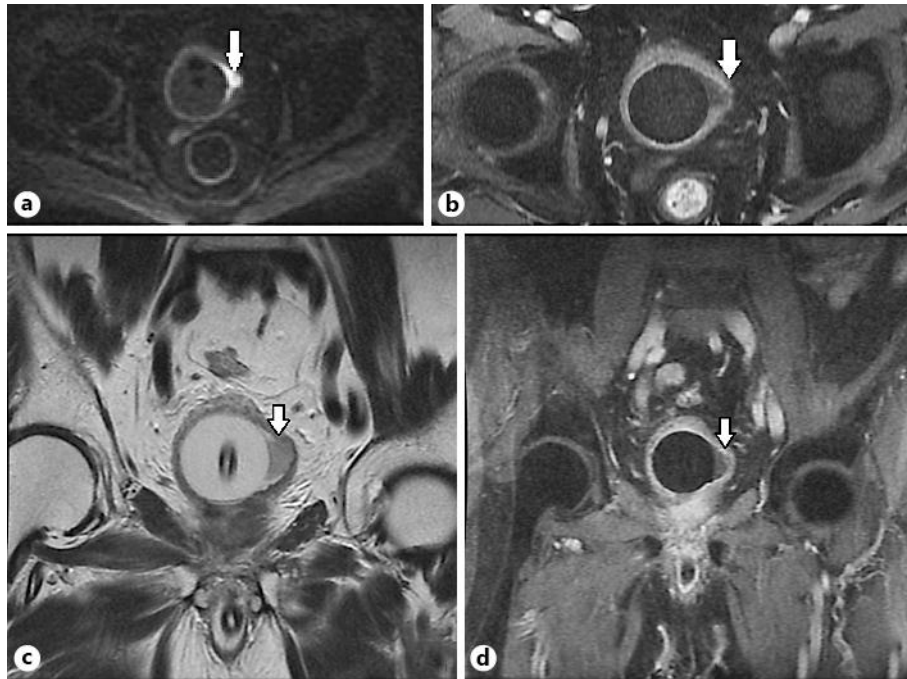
MRI (diffusion weighted image) shows less signal attenuation with the size of 11 × 14 mm that was observed on the left wall (a). Gd dynamic study shows the thin bladder wall (b). Coronal view of T2 imaging (c). Coronal view of Gd dynamic study (d). Arrows indicate the tumor.
